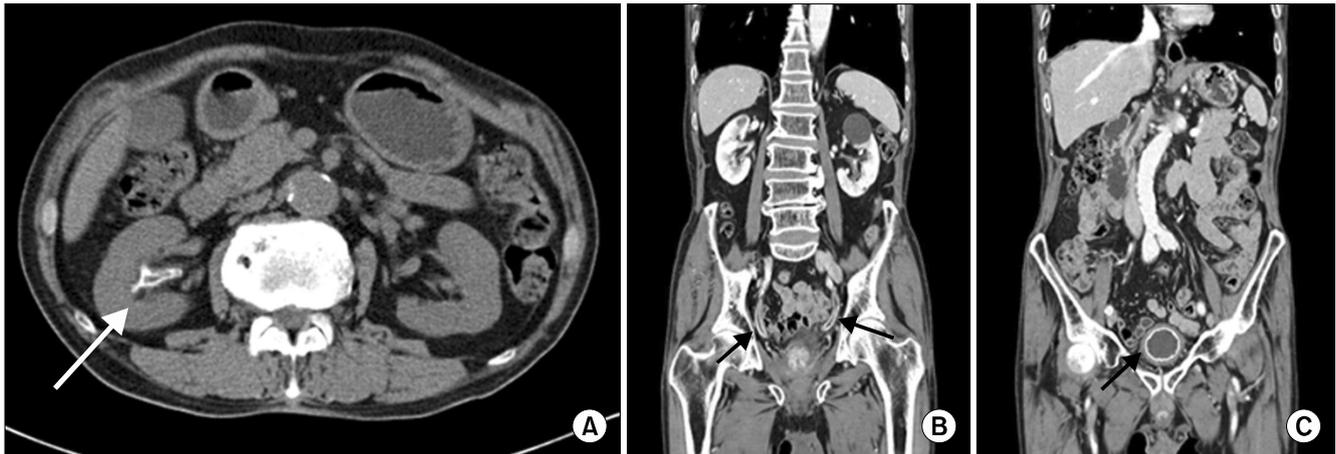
Abdomino-pelvic computed tomography (CT) images. (A) Non-contrast enhanced CT shows bilateral mild hydronephrosis with calcifications of the right renal pelvis (arrow). Enhanced CT shows calcification of ureter (B, arrows) and urinary bladder (C, arrow).
